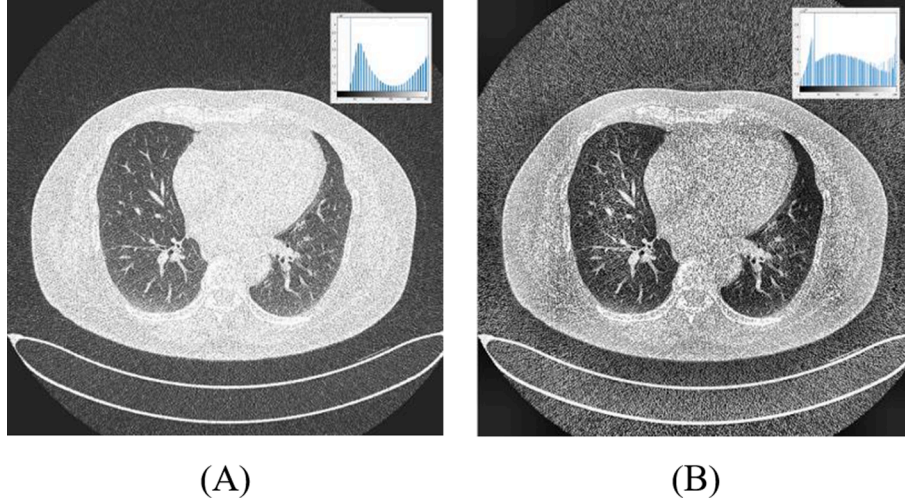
A sample example of contrast enlargement based on the CT image on the DSHE basis (A) original image, and (B) contrast-enhanced image.
